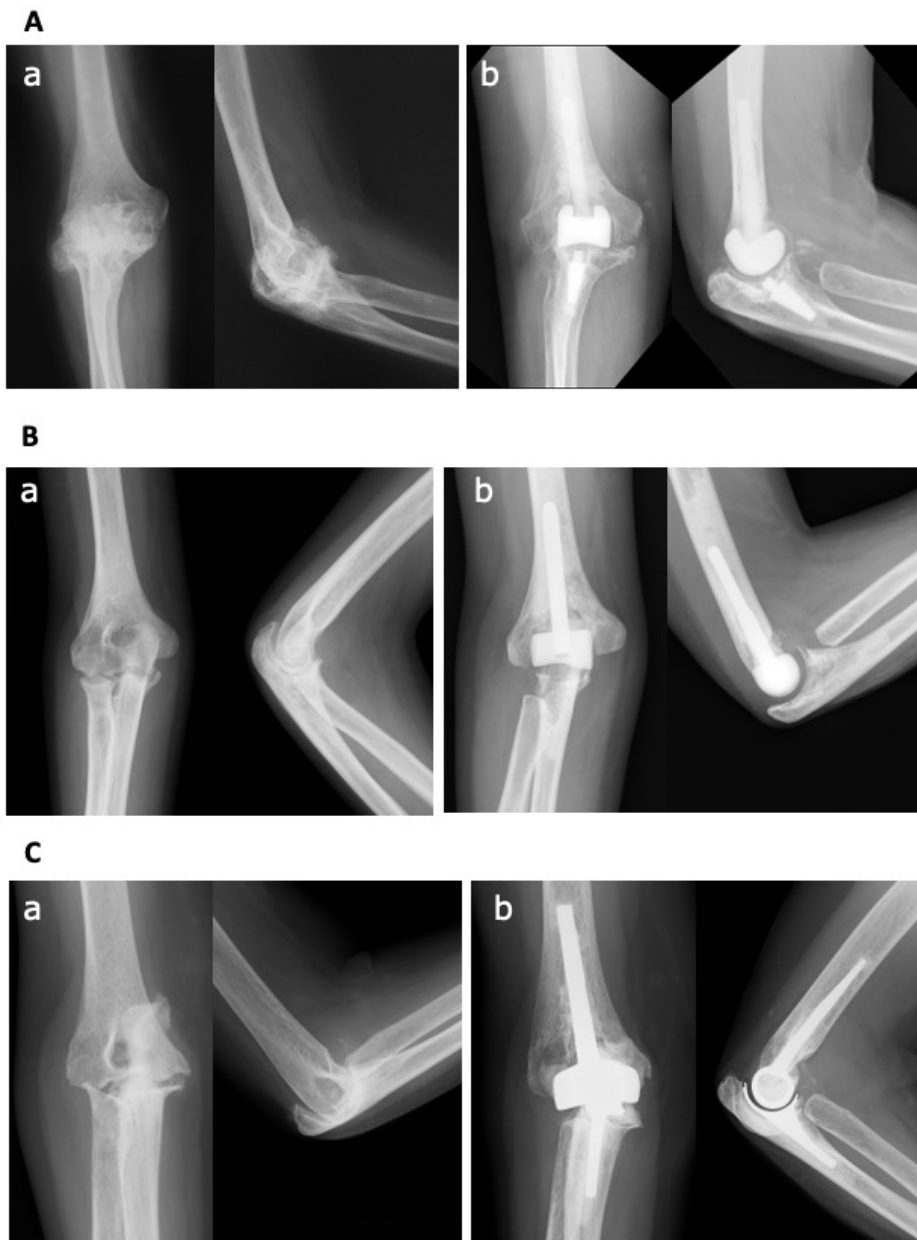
Fig a. Representative pre- and postoperative anteroposterior and lateral radiographs of the elbows after total elbow arthroplasty using three implants. A: a) Preoperative radiographs of right elbow of a 47-year-old woman replaced by Stemmed Kyocera type-I and b) postoperative radiographs 27 years after surgery. Flexion/extension ($^{\circ}$), pronation/supination ($^{\circ}$), and Mayo Elbow Performance
